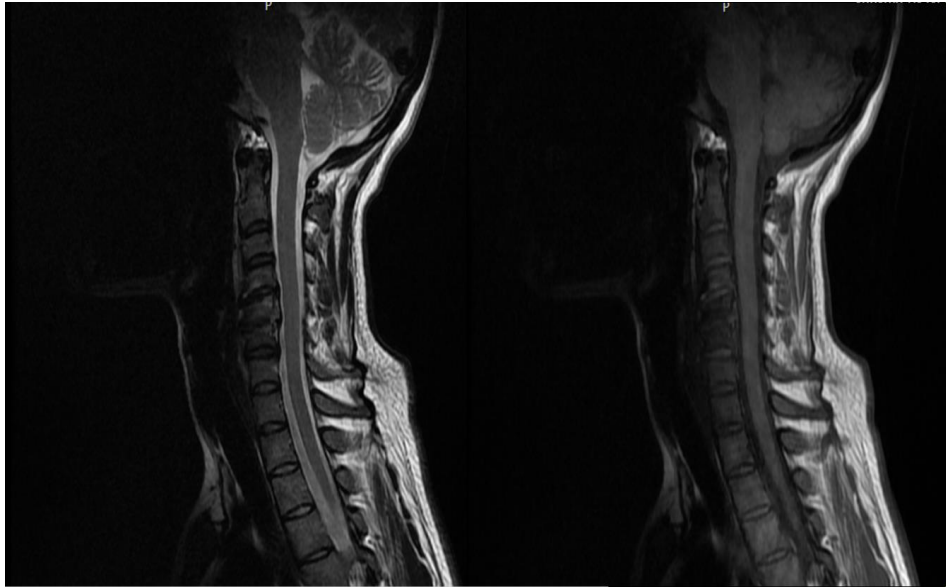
T1 and T2 MRI findings
